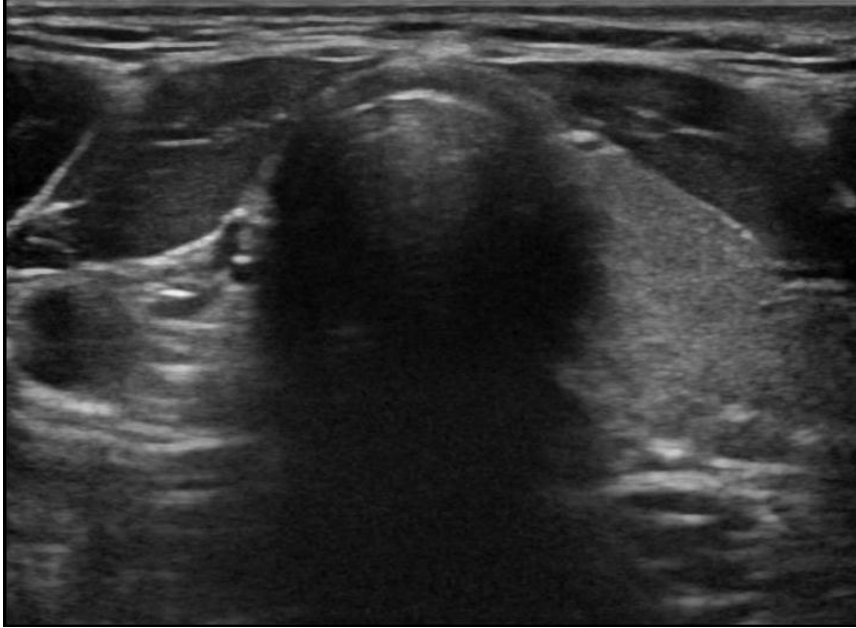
Ultrasonography transverse section of lower neck showing normal left thyroid lobe, absent right thyroid lobe and isthmus.
